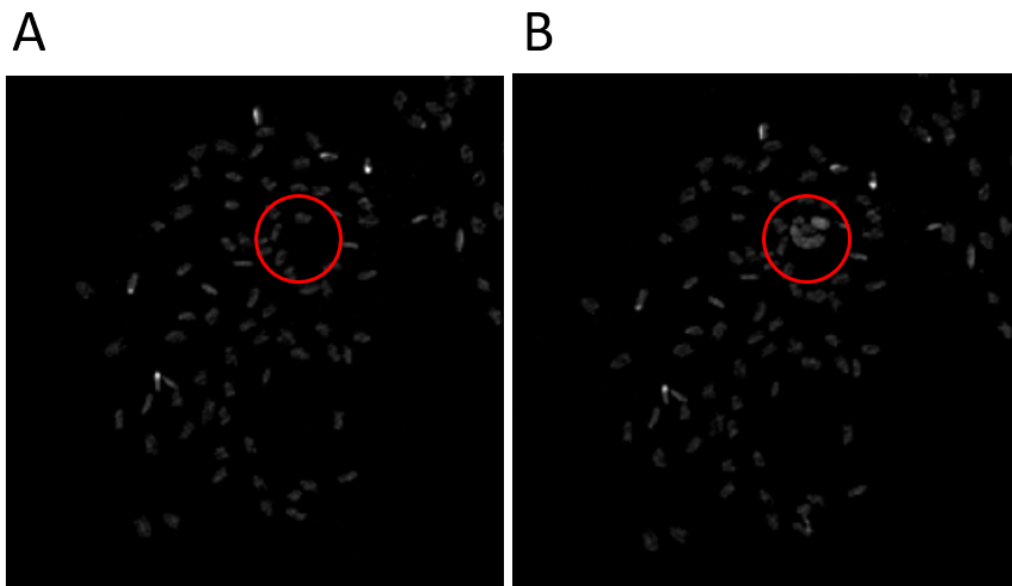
Example of signal interference on μ CT. A) shows a cross-section of filaments. B) shows the cross-section a few images down where filaments appear to have merged in higher intensity. The images were taken from Upright repeat 3 section 1.5-1.8 as referenced in Table 2.1
